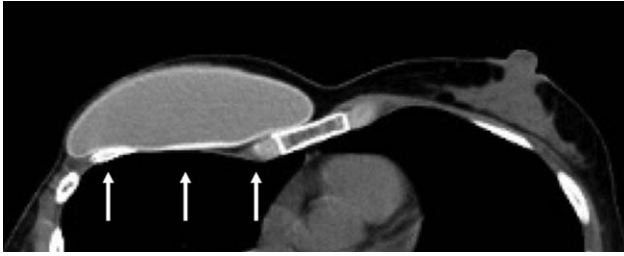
Chest wall evaluation using computed tomography after the second surgery to place the breast prosthesis. White arrows indicate remarkable worsening of chest wall depression deformity after the surgery.
